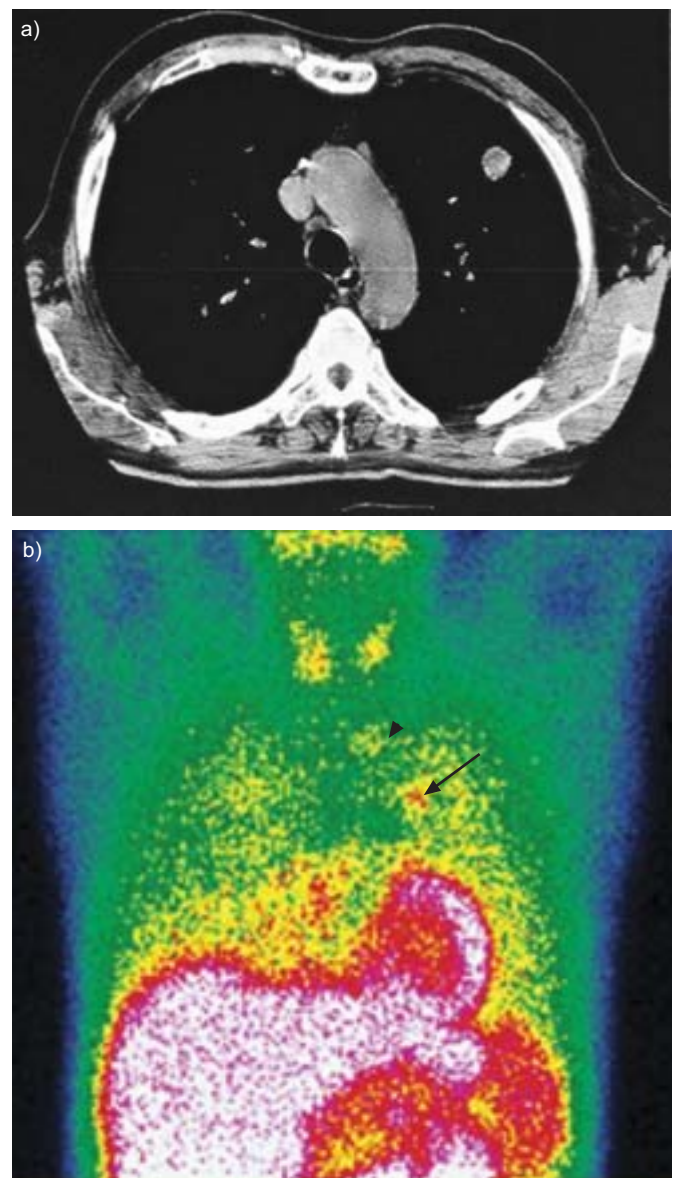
Chest computed tomography (CT) of a 61-yr-old male patient with a solitary pulmonary nodule in the left upper lobe. a) The chest CT scan showed a 1-cm lesion without mediastinal or hilar lymphnode enlargement. b) Planar views and coronal slices showed increased uptake in the nodule (score 3; arrow), as well as uptake in ipsilateral mediastinal lymphnode (arrowhead). Surgical resection showed adenocarcinoma in the nodule and in the N2 lymphnode.
